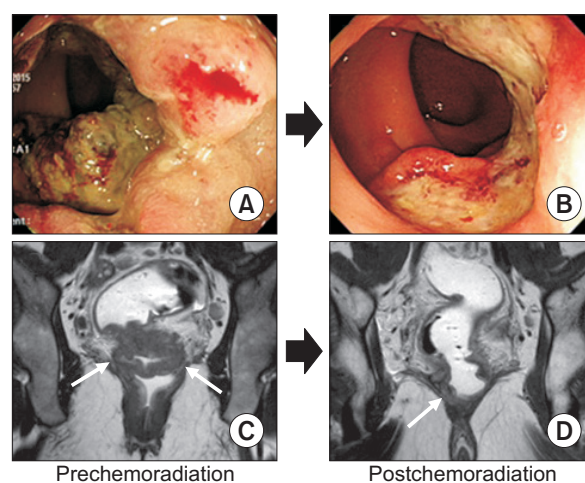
Comparison of colonoscopic and magnetic resonance imaging before and after chemoradiation. (A) Huge ulcerofungating lesion in the low rectum. (B) Partial regression of the tumor after chemoradiation. (C) Annular mass involving the low rectum with a positive circumferential resection margin at the left and right levator-ani muscle (white arrows). (D) Decreased extent of tumor with a still threatening circumferential resection margin at the right levator-ani muscle (white arrow).
